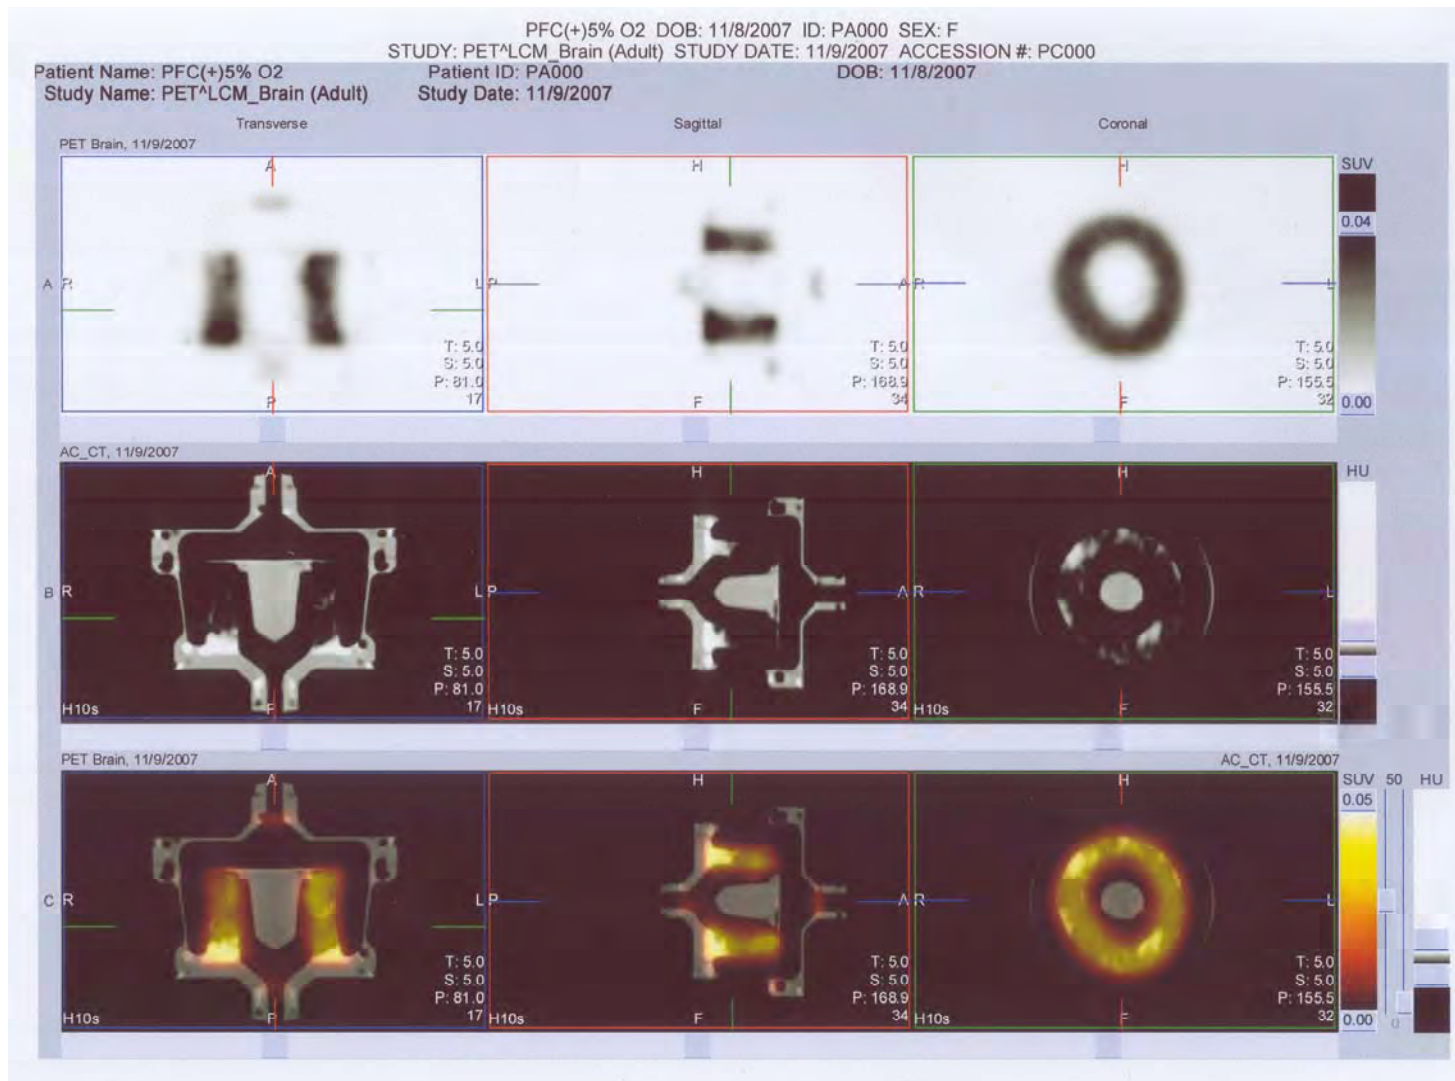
CT and PET scan of hypoxic gas mix cell-seeded bioreactor *with* PFC. PFC(+) bioreactors were all ‘cooler’ having absorbed less glucose, i.e. less a glycolytic metabolism than PFC(-) bioreactors.
